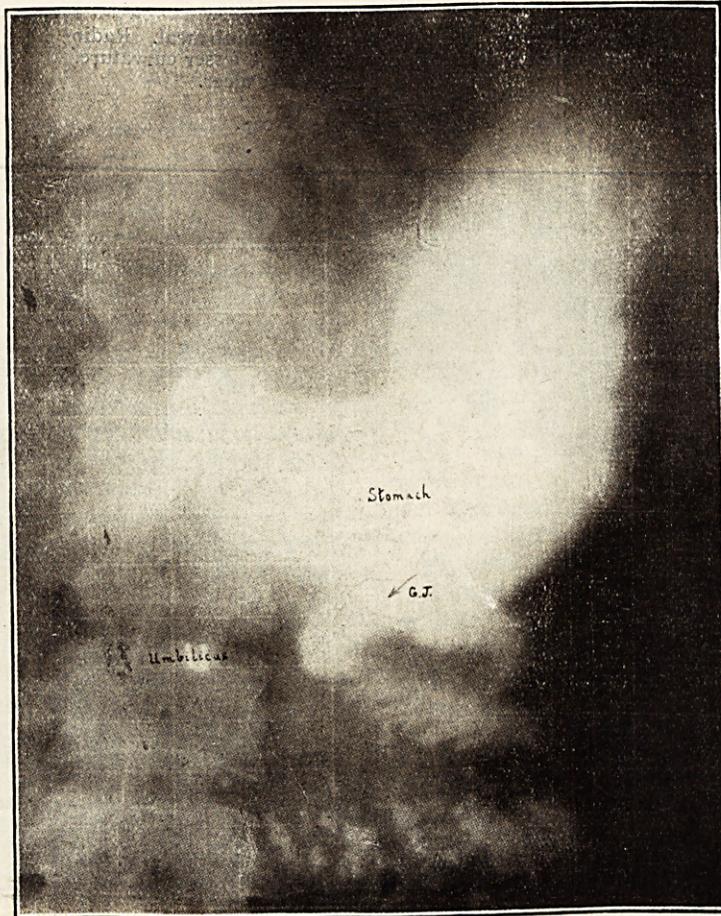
Patient operated on 6 months previously for Duodena ulcer. Gastro-jejunostomy performed. Examination $\frac{1}{2}$ hour after the Bismuth meal. Radiograph shows the Bismuth passing through the Gastro-jejunostomy opening. Nil passing through pylorus. G. J. = Gastro-jejunostomy.
